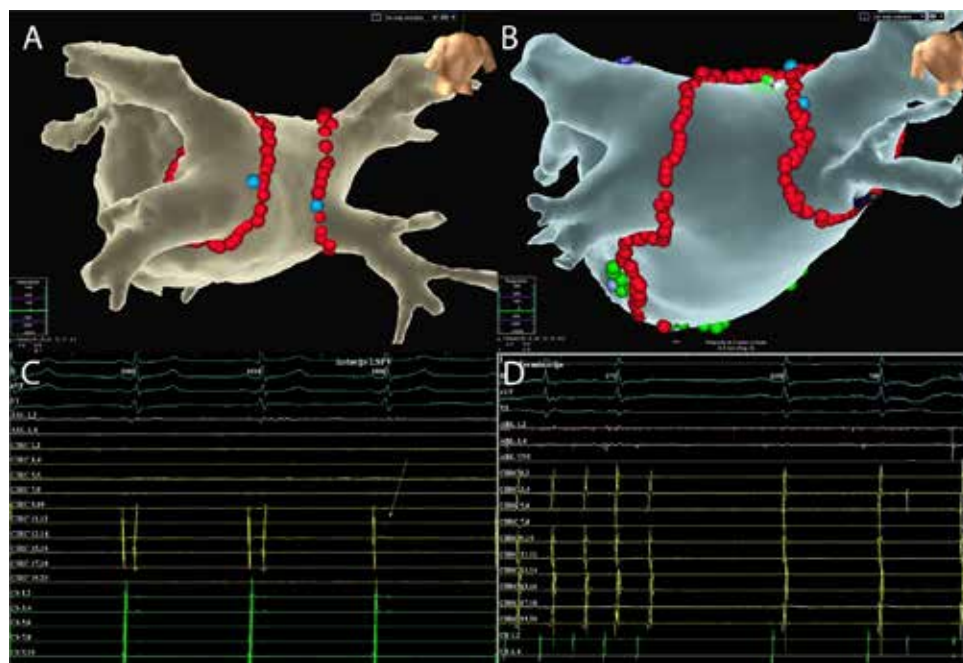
Panel A displays PVI ablation lesion set as ablation strategy in patient presented as Case 1 (PV isolation circumferential lines, encircling the ipsilateral PV pairs). Panel B displays ablation lesion set as ablation strategy in patient presented as Case 2 (PVI + additional substrate ablation). Panels A and B showing the posterolateral and posterior view of the LA model fused with computed tomography image. Radiofrequency lesions were tagged as the 4-mm diameter red balls. On panel B additional substrate ablation is presented (roof line connects the most cranial points of the left-sided and right-sided PVI circles; mitral line extends from the lateral mitral annulus to anteroinferior segment of left PVI, adjacent to left inferior PV ostium). Panel C presents the intracardiac signals and a moment of left sided PVI (yellow arrow) in patient presented as Case 1. Panel D points the moment of AF termination during procedure in patient presented in Case 2.
